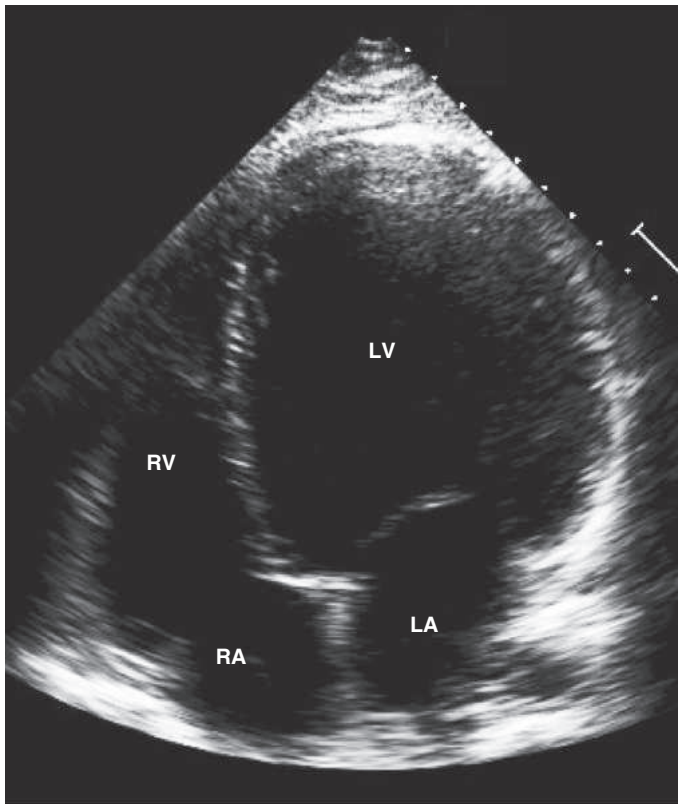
Dilated cardiomyopathy. This echocardiogram of a young man with dilated cardiomyopathy shows massive global dilation and thinning of the walls of the left ventricle (LV). The left atrium (LA) is also enlarged compared to normal. Note that the echocardiographic and pathologic images are vertically opposite, such that the LV is by convention on the top right in the echocardiographic image and bottom right in the pathologic images. RA, right atrium; RV, right ventricle. (Image courtesy of Justina Wu, MD, Brigham and Women's Hospital, Boston.)
